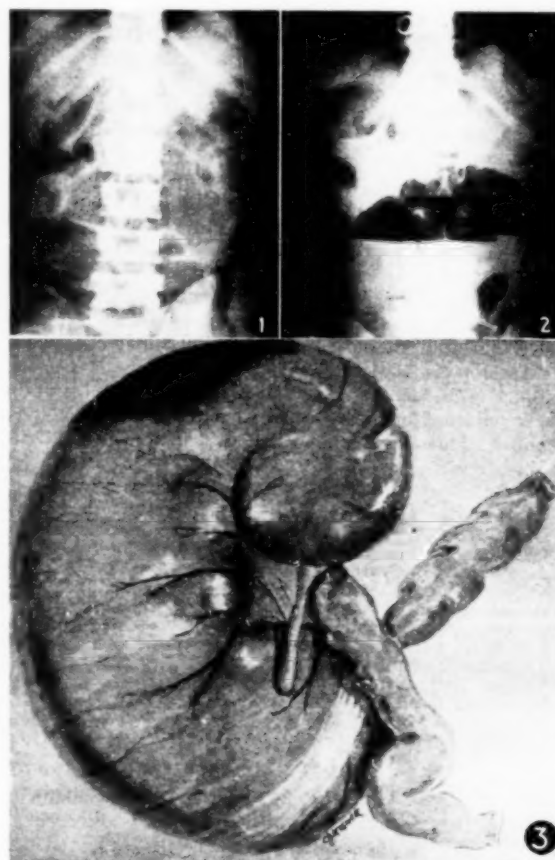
Flat X-ray of the abdomen with the patient prone, revealing the distention in the colon on the right side.
